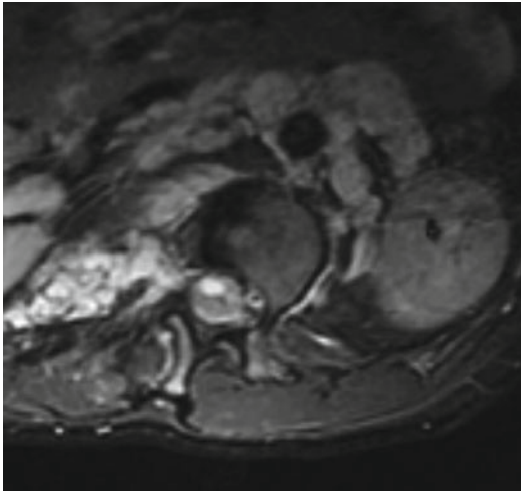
MRI of the spine with the neurofibroma in canal. Bright shadow depicts neurofibroma exiting through the spinal canal. The constriction of the neurofibroma in the foramen gives it the appearance of a dumbbell
